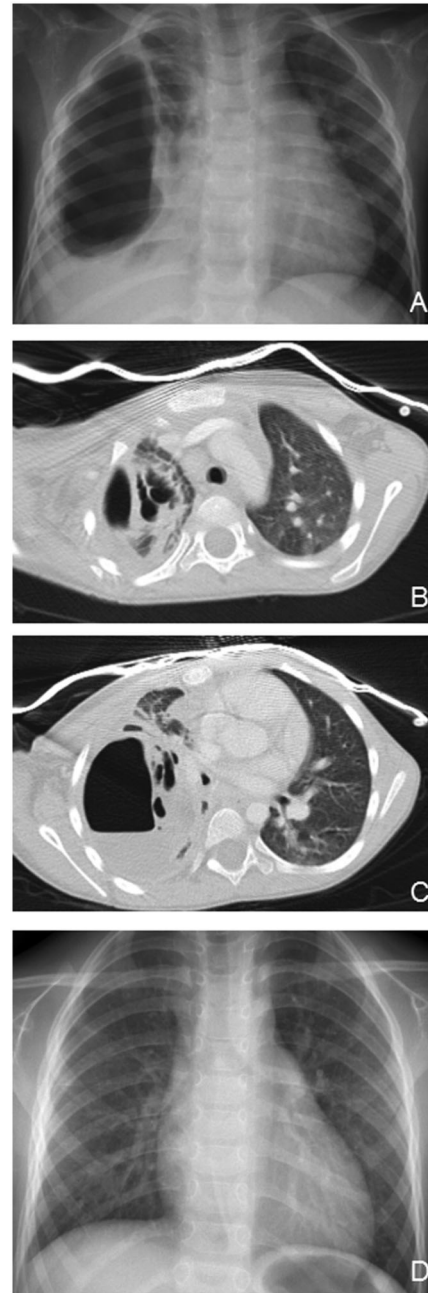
Radiography (A) and CT scan (B,C) showing massive hydropneumothorax and necrotizing pneumonia. Complete radiographic resolution 5 months later (D).
